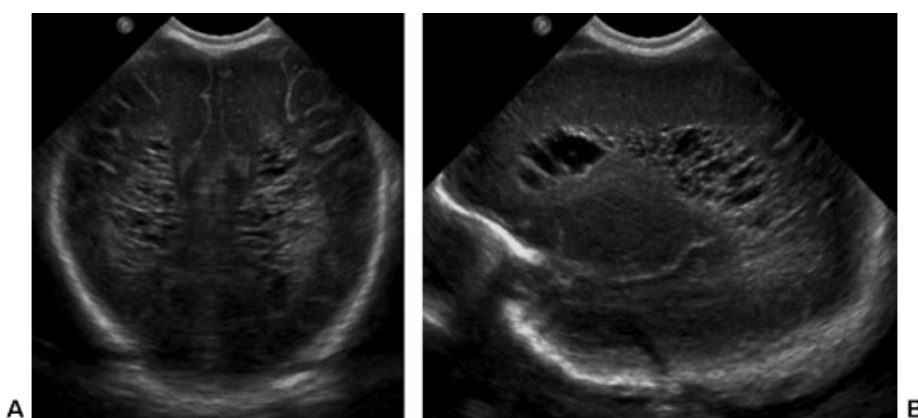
(A) Coronal and (B) sagittal cranial ultrasound at 27 days of life showing cystic degeneration of prior echodensities.
